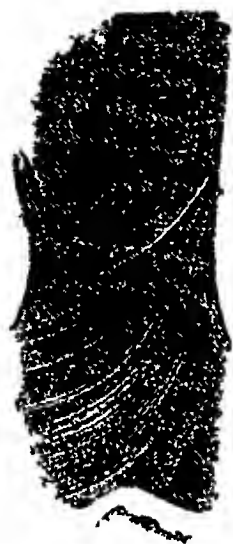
Cartilaginous exostosis with cartilaginous extremity thus not discernible in the X-Ray picture
